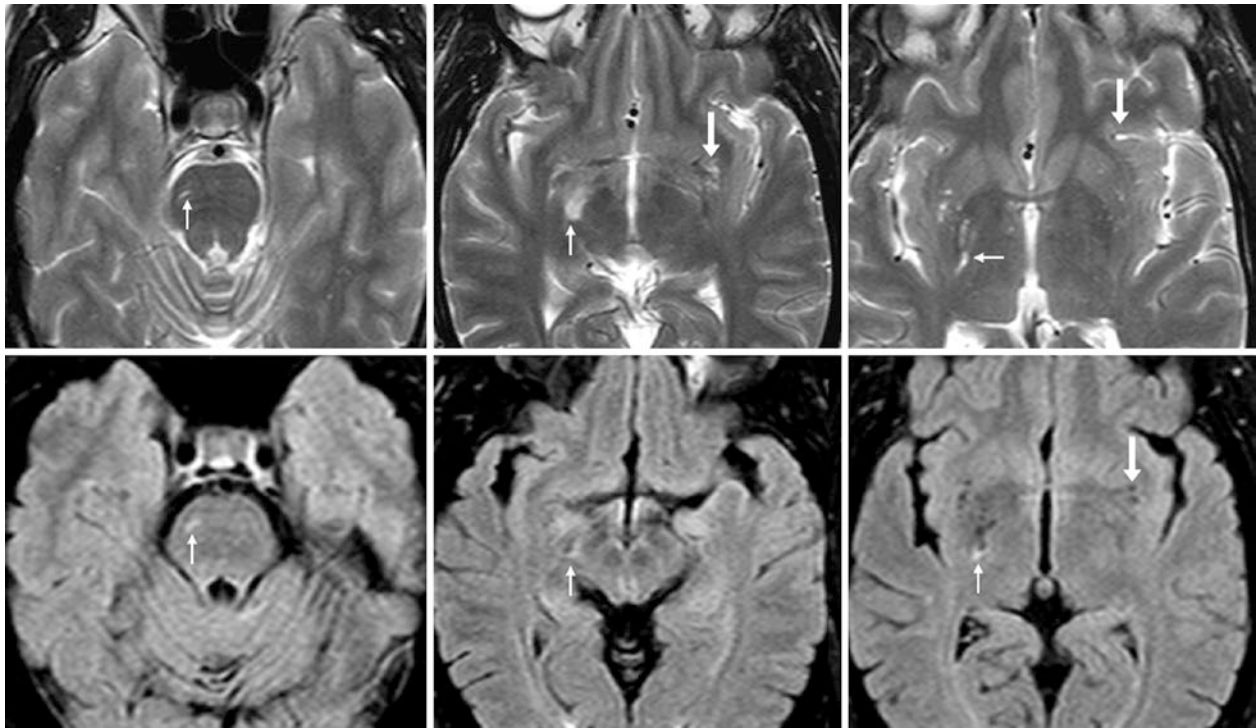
Comparison case of chronic insult and gliosis amid dilated PVSS. A 35 year old boxer with upper motor neuron signs underwent an MRI, which showed normal dilated PVSs within the left anterior perforated substance (arrows) on T2WI (top row) that suppressed on FLAIR
